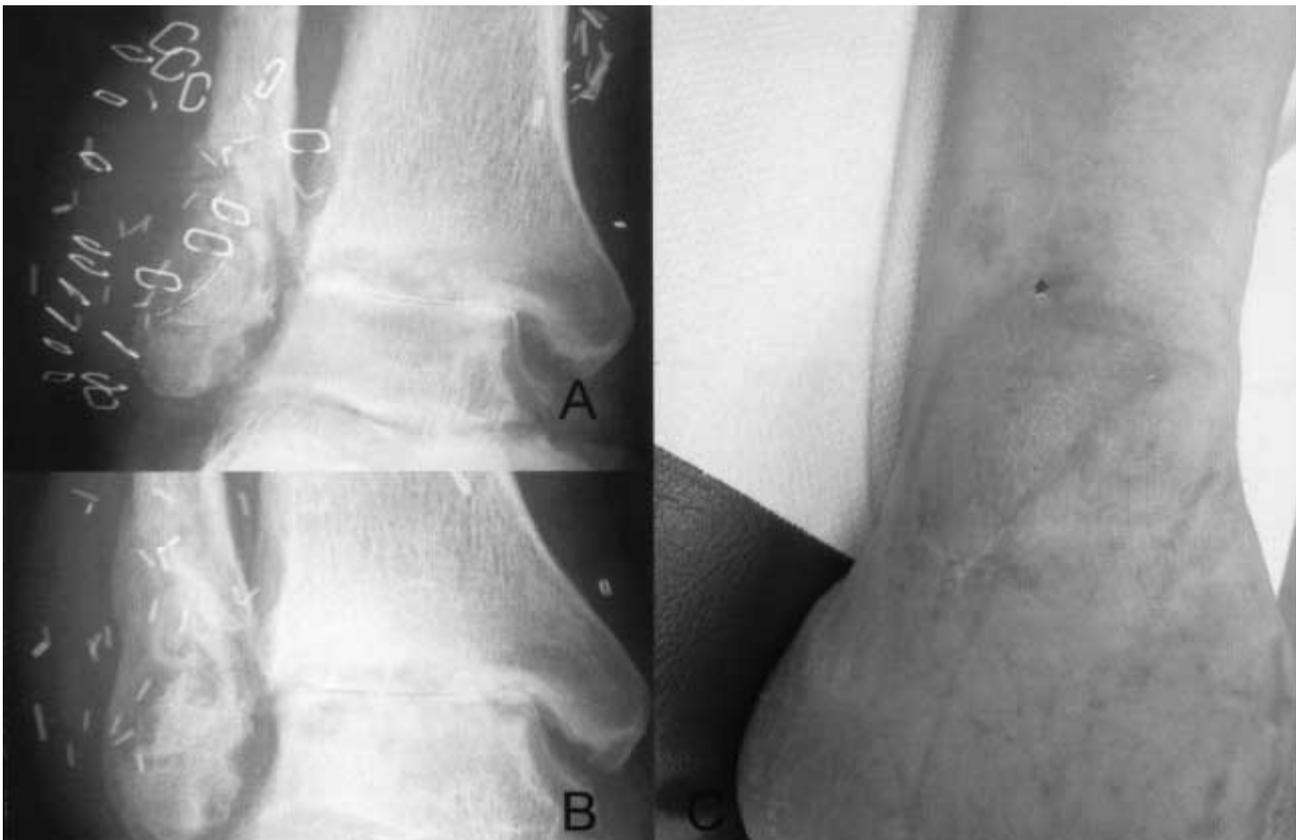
Open fracture of the lateral malleolus. Early postoperative (A) and late postoperative radiograph with good callus formation (B). Clinical result 6 months after flap transfer (C).
